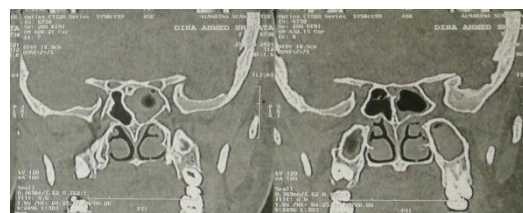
CT scan showing sphenoid and maxillary sinusitis and nasal turbinate enlargement.
